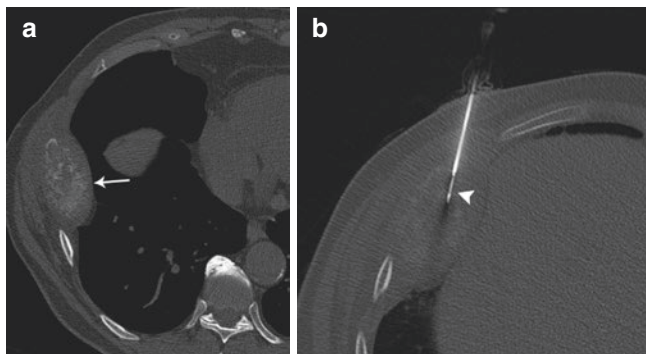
(a) CT-guided bone biopsy of an expansile sclerotic metastatic lesion involving the right 5th rib (*arrow*). (b) A coaxial bone biopsy system is introduced using a tangential oblique approach to reduce the risk of damage to the pleura (*arrowhead*)
